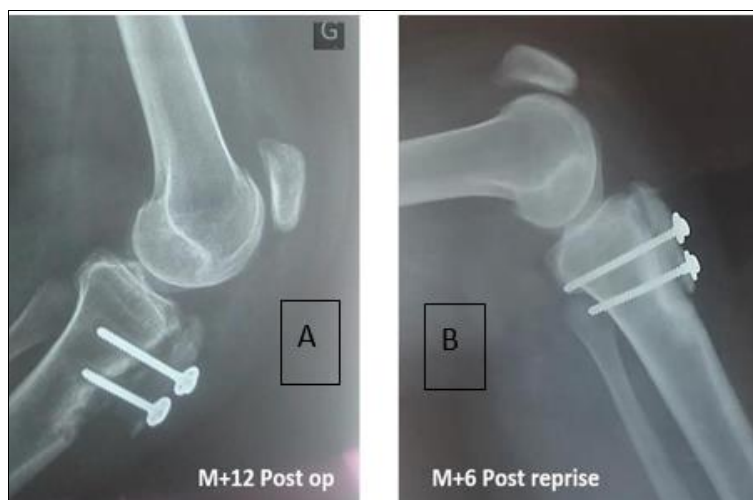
Case of a permanent dislocation evolving for 5 years: (A) Preoperative X-ray (B) Postoperative X-ray with luxation reduction + TTA transfer + trochleoplasty.
